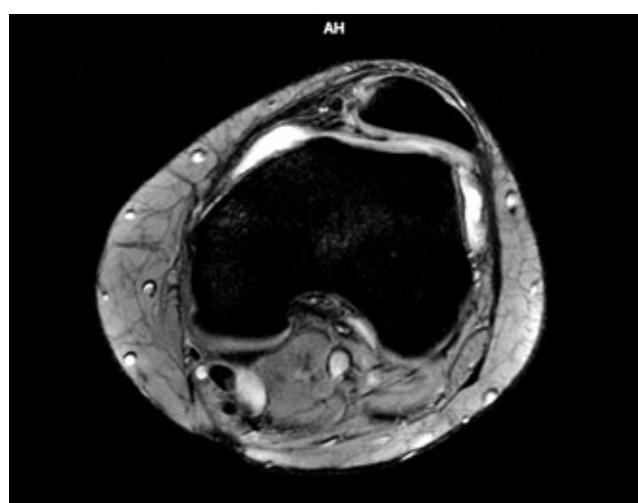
Axial T2 MRI slice of the left knee. Dejour type B trochlea dysplasia. The sulcus angle is increased, the trochlea is convex, the patella is lateralized, and there are early degenerative changes on the lateral edge of the trochlea.
